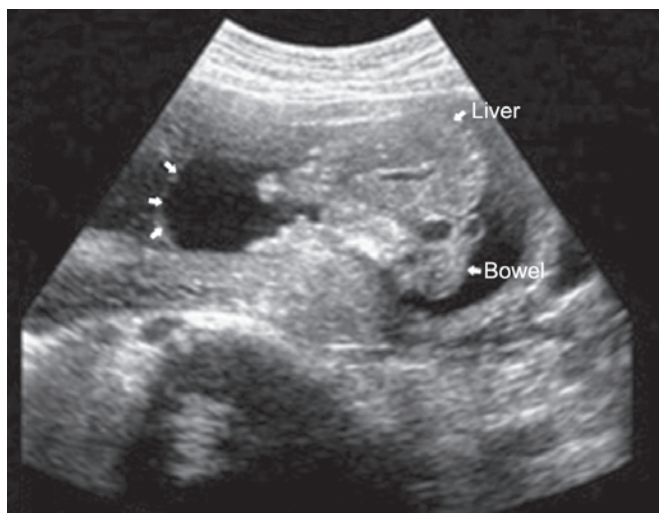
Antenatal ultrasound at 23 weeks 1-day gestation demonstrating the covering of the omphalocele (arrows on the left) and the herniated liver and bowel loops. Ectopia cordis is also present
